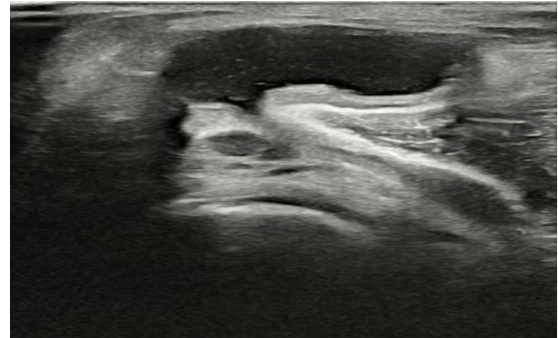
Ultrasonography of osteophytes in femorotibial joint of the patient.
